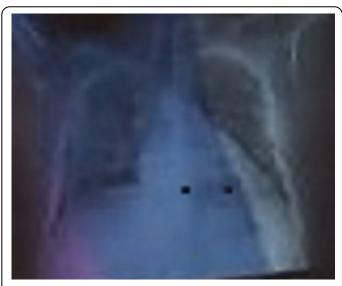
Showing chest X-Ray of our patient with bilateral lung infiltrations.
